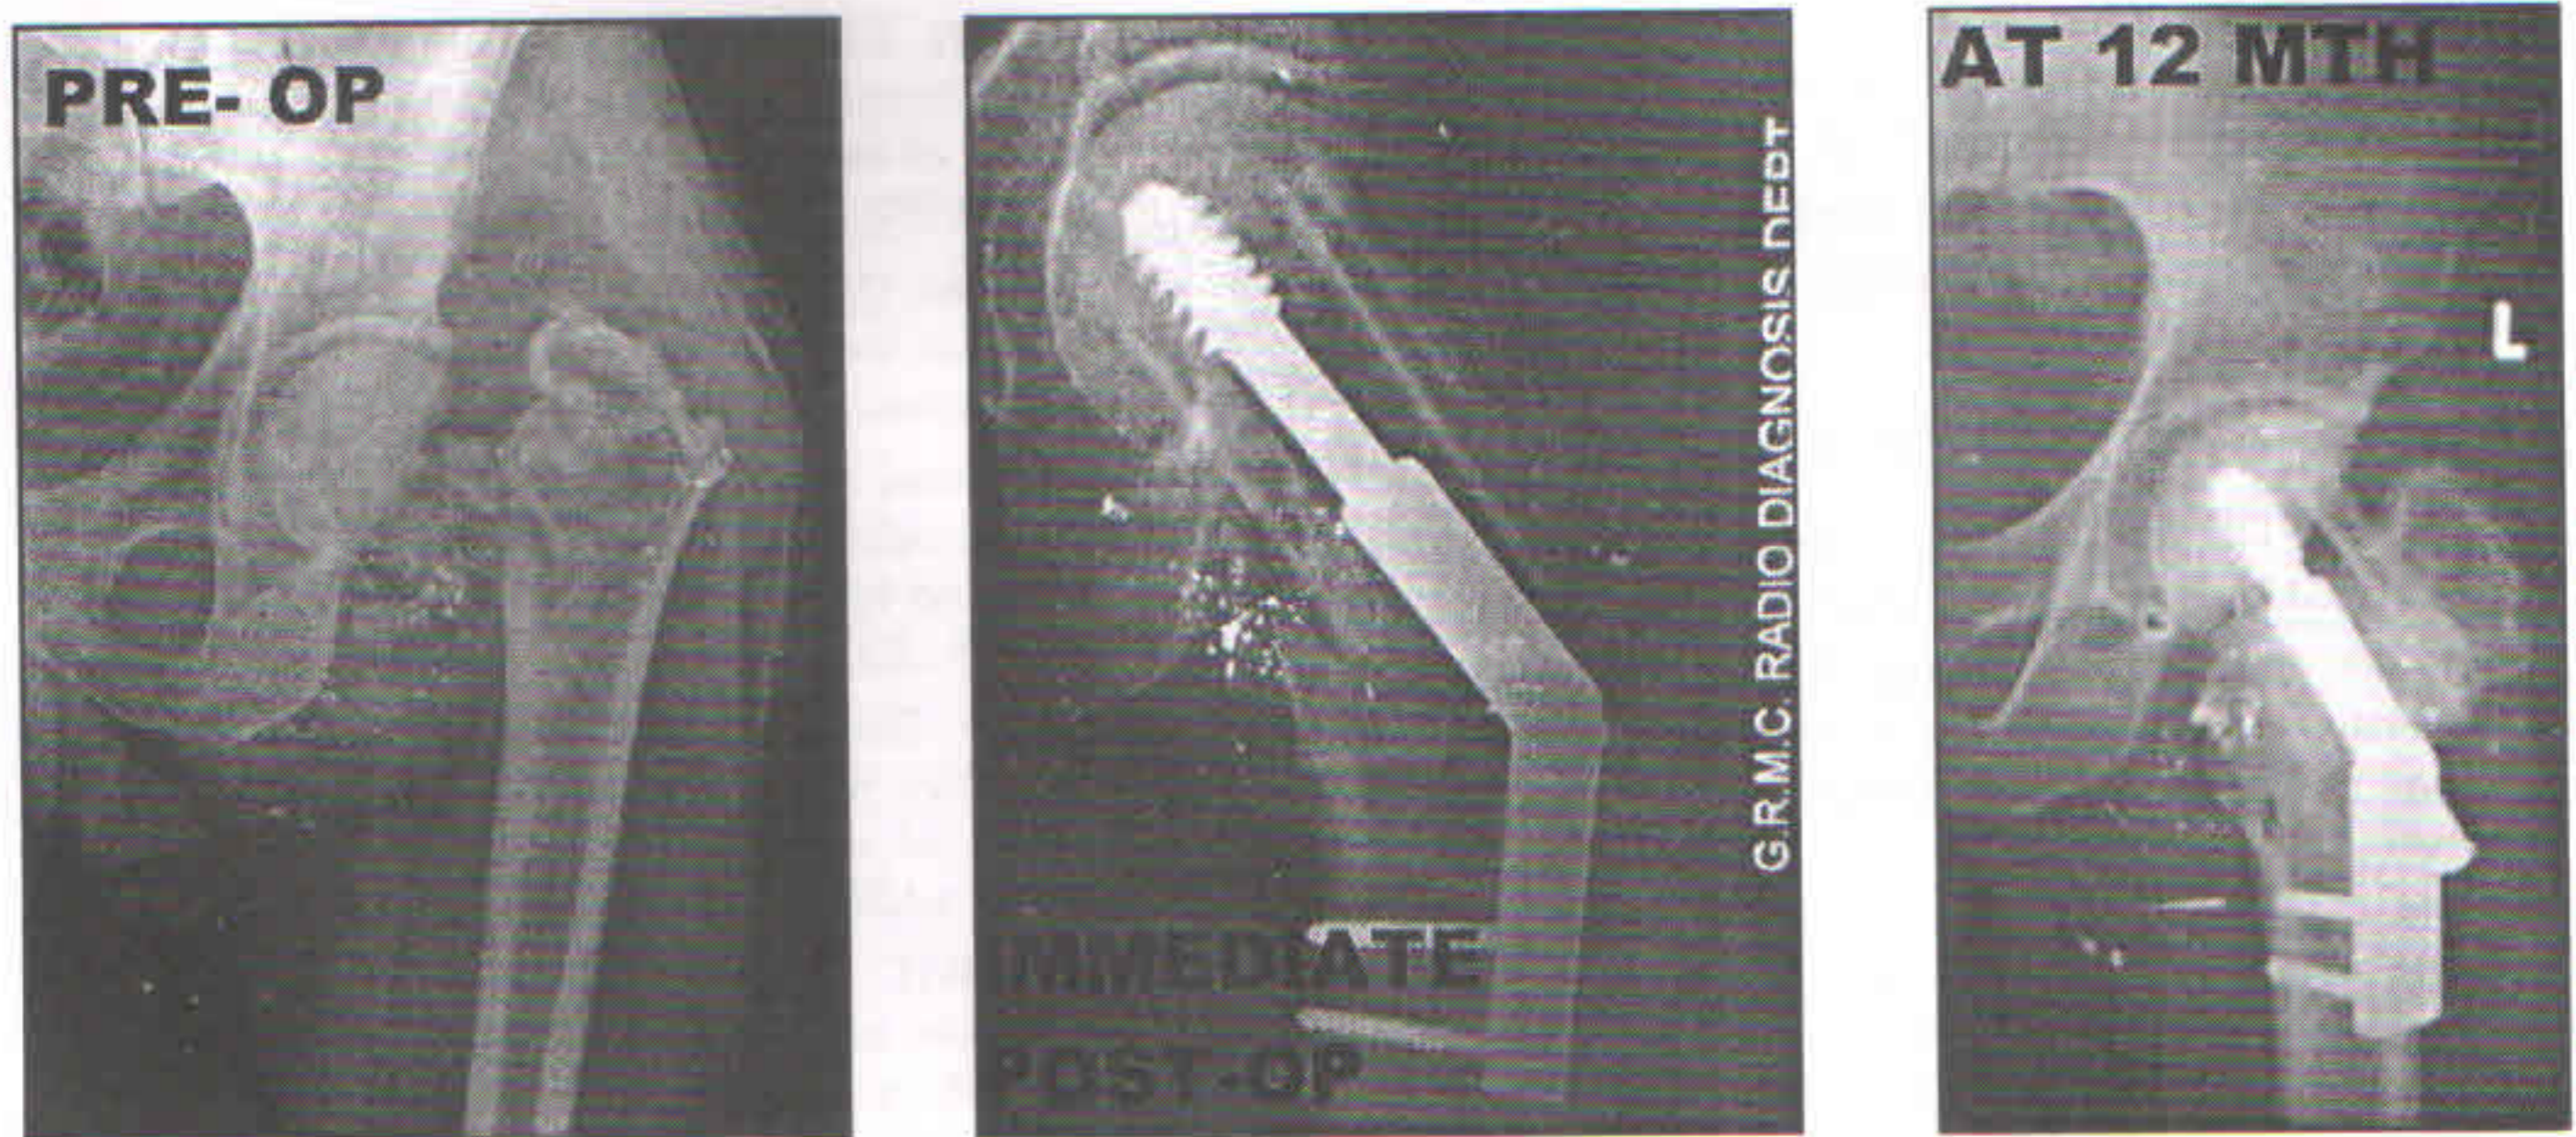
Xray of a patient with neglected fracture of femur neck treated with osteosynthesis and double fibula
